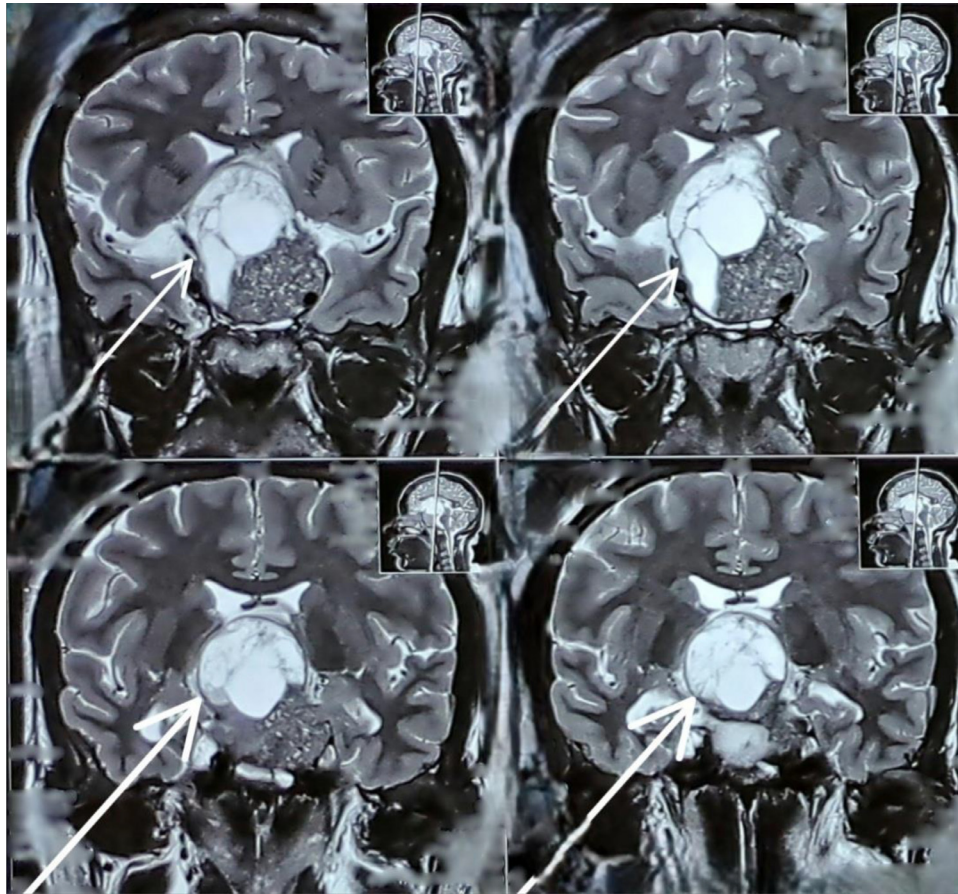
Coronal T2-weighted MRI demonstrating a large, hyperintense pituitary macroadenoma within the sella turcica, extending into the suprasellar region (marked by arrows). The lesion displaces the optic chiasm and exhibits well-defined borders, suggesting potential mass effect.
